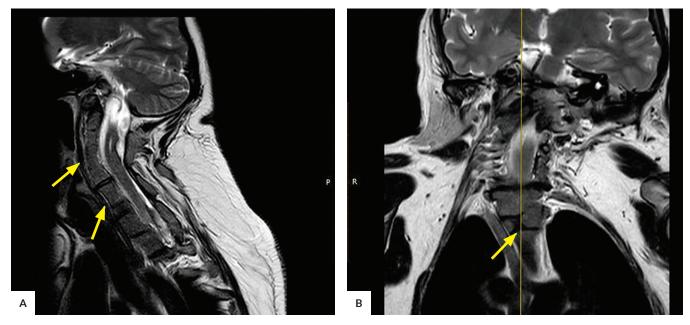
MRI of the spine showing (A) multiple vertebral fusion anomalies at C2- C7 (yellow arrows) and (B) midline fusion defects (yellow arrow) compatible with Klippel-Feil Syndrome.
